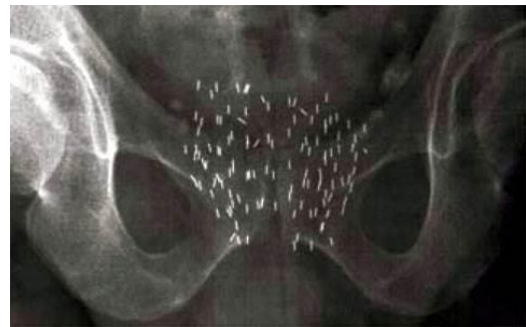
X-ray of radioactive seeds implanted for treatment of prostate cancer
